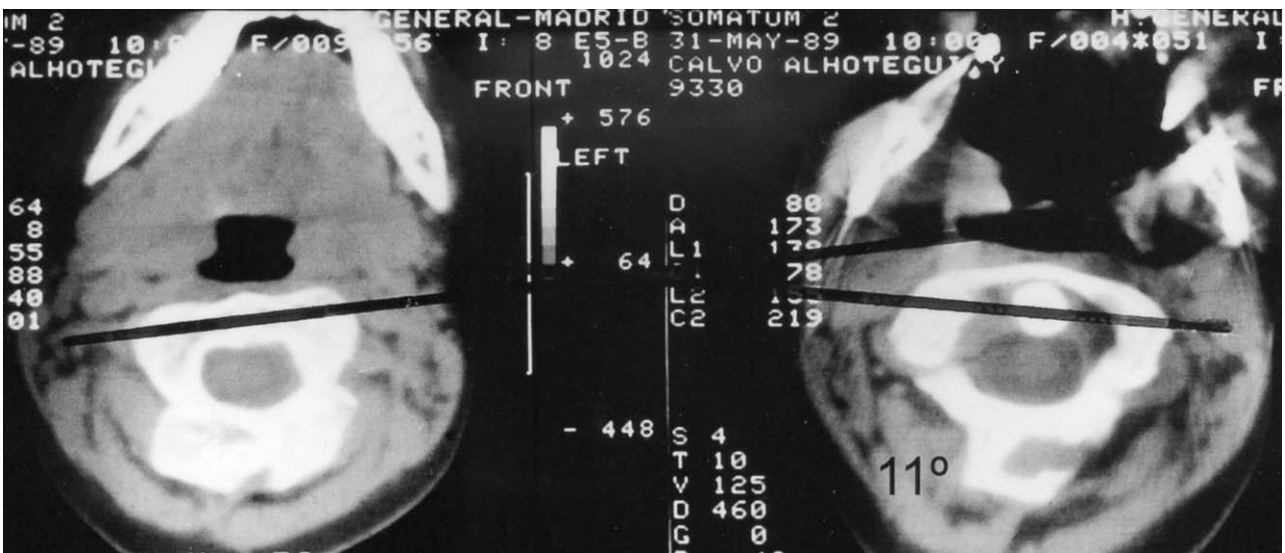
Postsurgical CT scan of the first patient, where the satisfactory mass of arthrodesis and an 11° residual divergente are shown.
